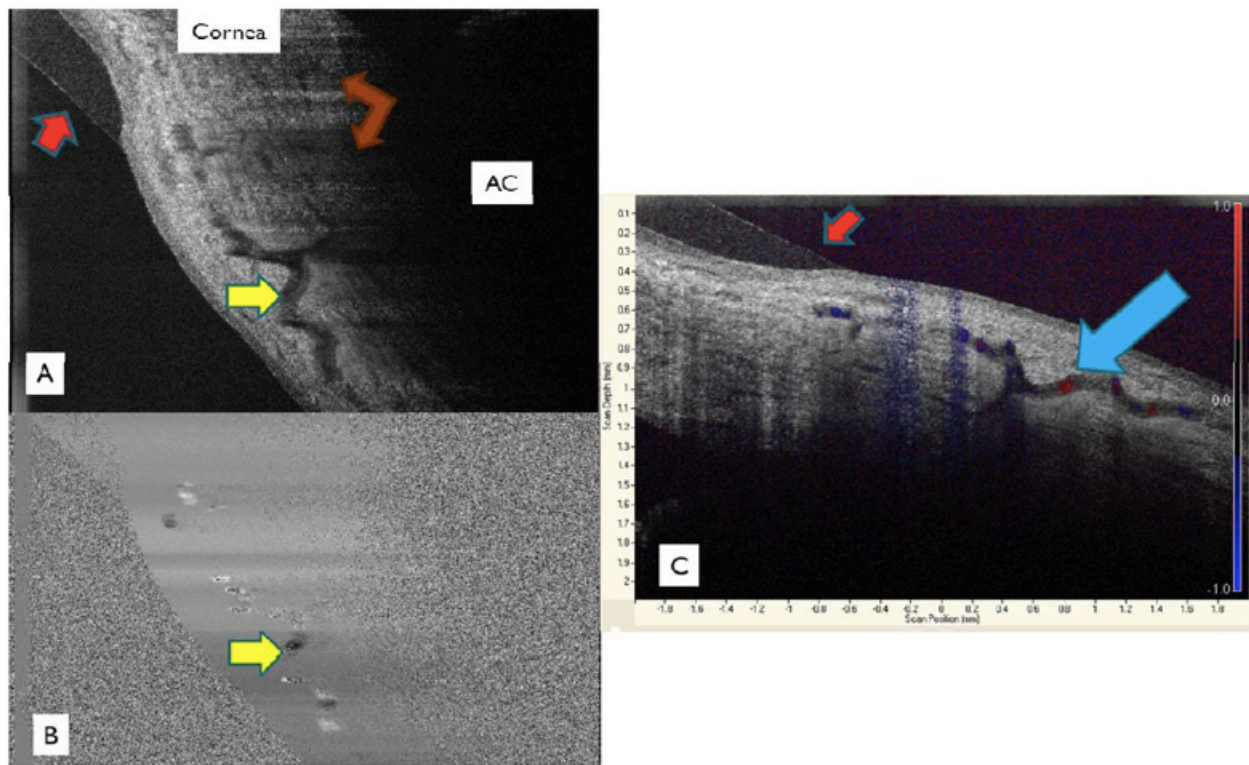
Doppler observed in a living human eye
